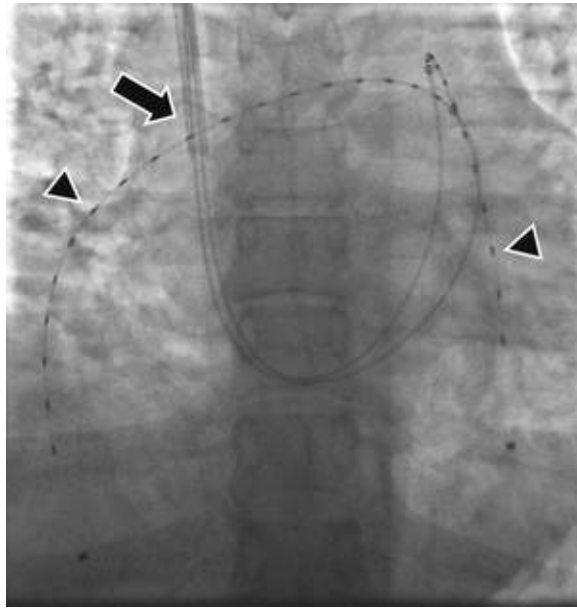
Bilateral low-power ultrasound–facilitated catheter-directed thrombolysis in a 20-year-old woman with massive PE. In the dual-catheter (*arrow*) system shown, the outer catheter has side holes to permit administration of fluids and medications such as alteplase. The inner sheath contains catheters with ultrasound transducers (*arrowheads*).
